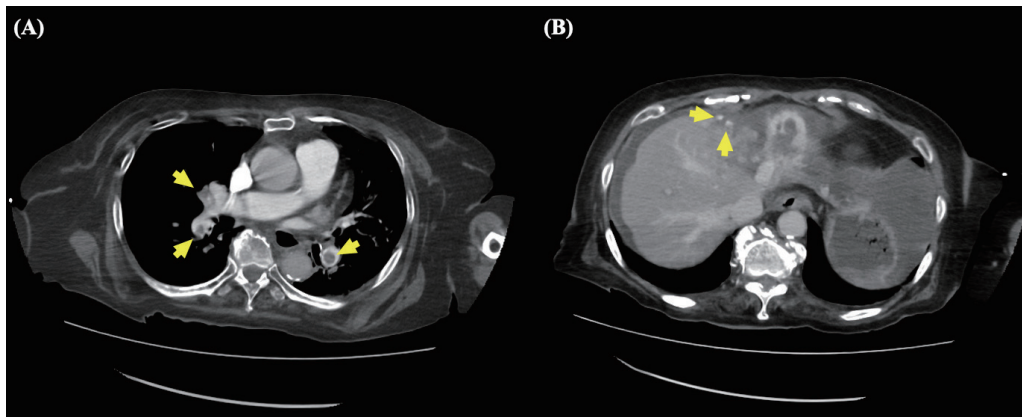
Contrast CT images showing massive PE (A) and hematoma around the liver (B). Arrowheads in (A) indicate blood clots. Arrowheads in (B) indicate bleeding spots in the liver.
